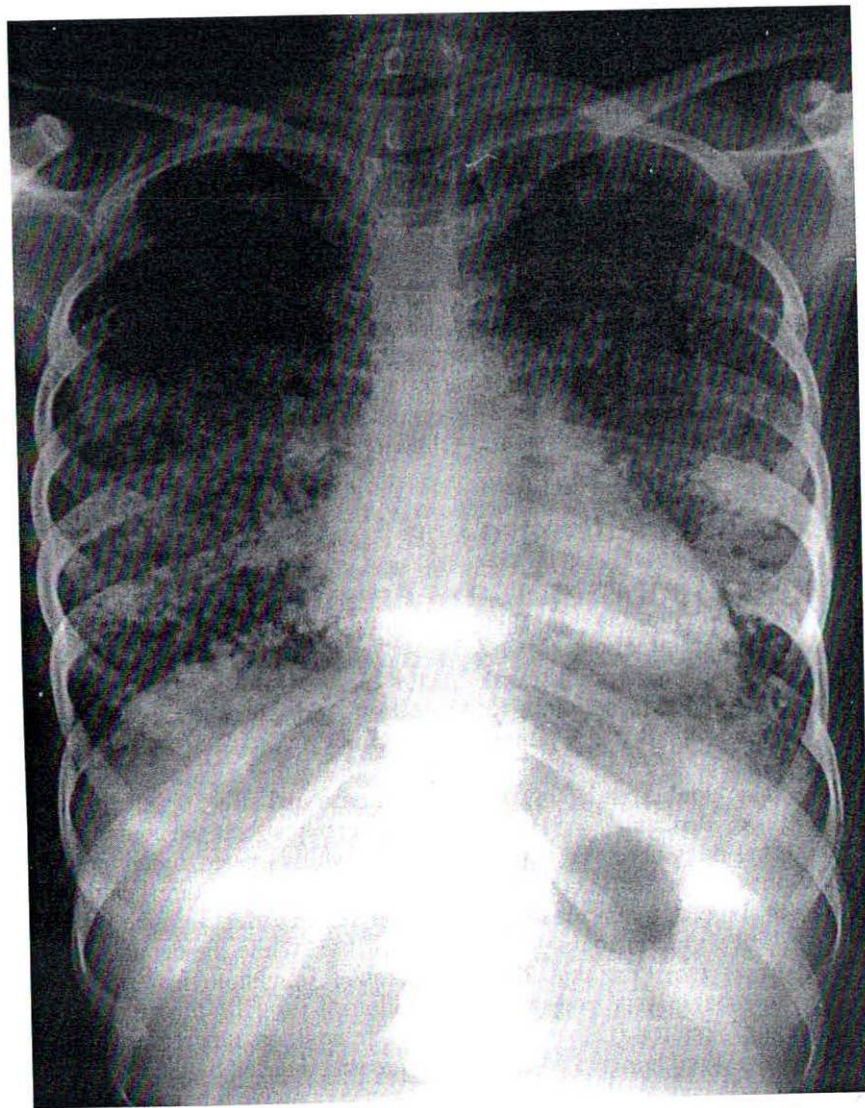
Pulmonary tuberculosis. Diffuse X-ray changes with nodular lesions in all zones and no cavitation. These changes are often seen in patients with a poor immune response to *M. tuberculosis*. Courtesy of Dr P. Ormerod
